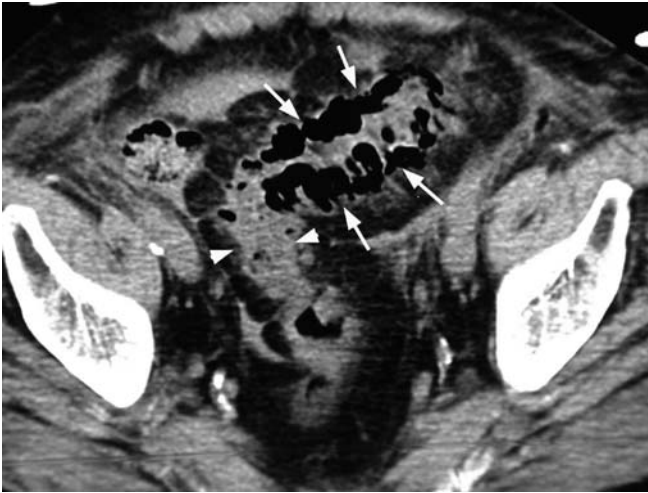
Sigmoid infarction. CT shows only mild wall thickening (*arrowheads*), but pronounced pneumatosis of the sigmoid colon (*arrows*)—a finding that must raise the suspicion of ischemia or infarction
